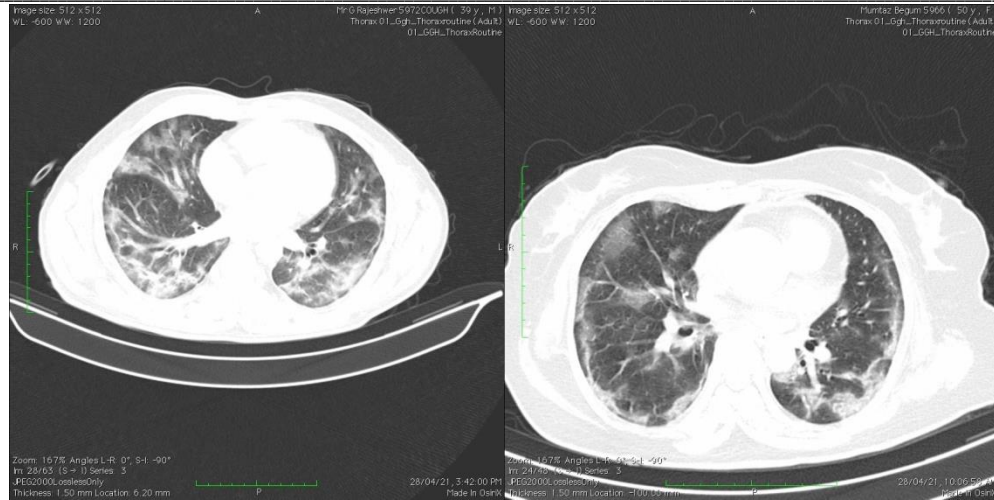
Thin sections of CT chest show bilateral multifocal subpleural ground glass opacites
